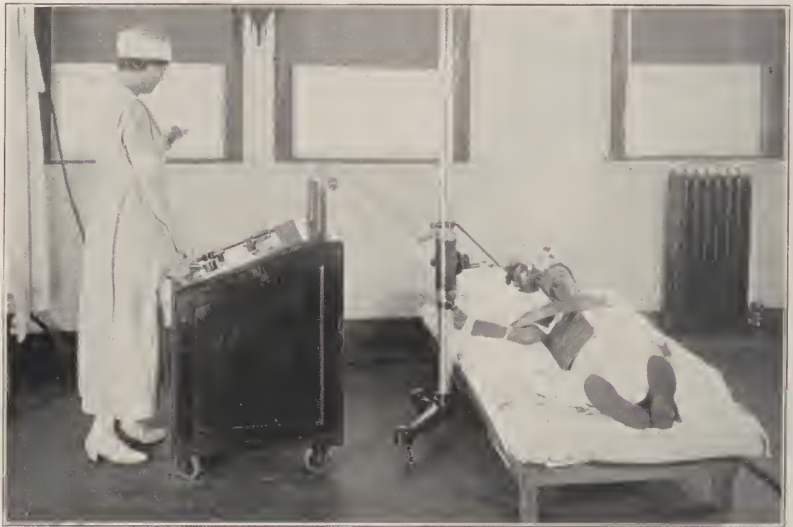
Low voltage ionizing x-ray therapy.
